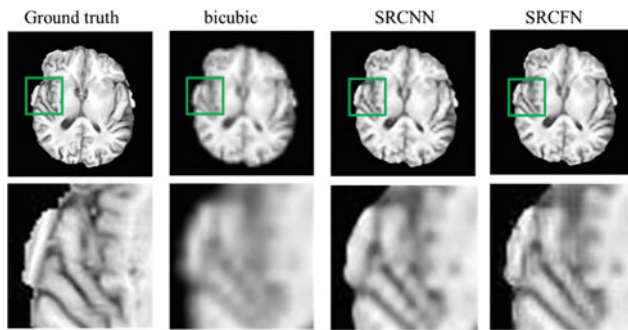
Qualitative comparison. 1 The first row shows qualitative comparison of three methods in MR image (brats_tcia_pat247_0001/44 slice). 2 The second row shows local detail of results
